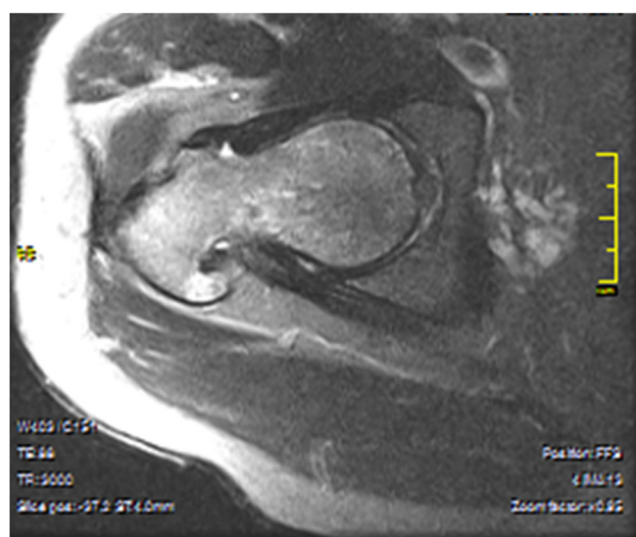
Repeated MRI 8 weeks following Fig. 1 revealed no femoral head collapse and persistent but improved edema with no fracture lines present, most consistent with TOH
